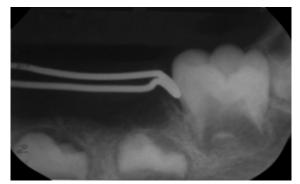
Intraoral periapical radiograph showing the modified appliance on the left side before cementation
